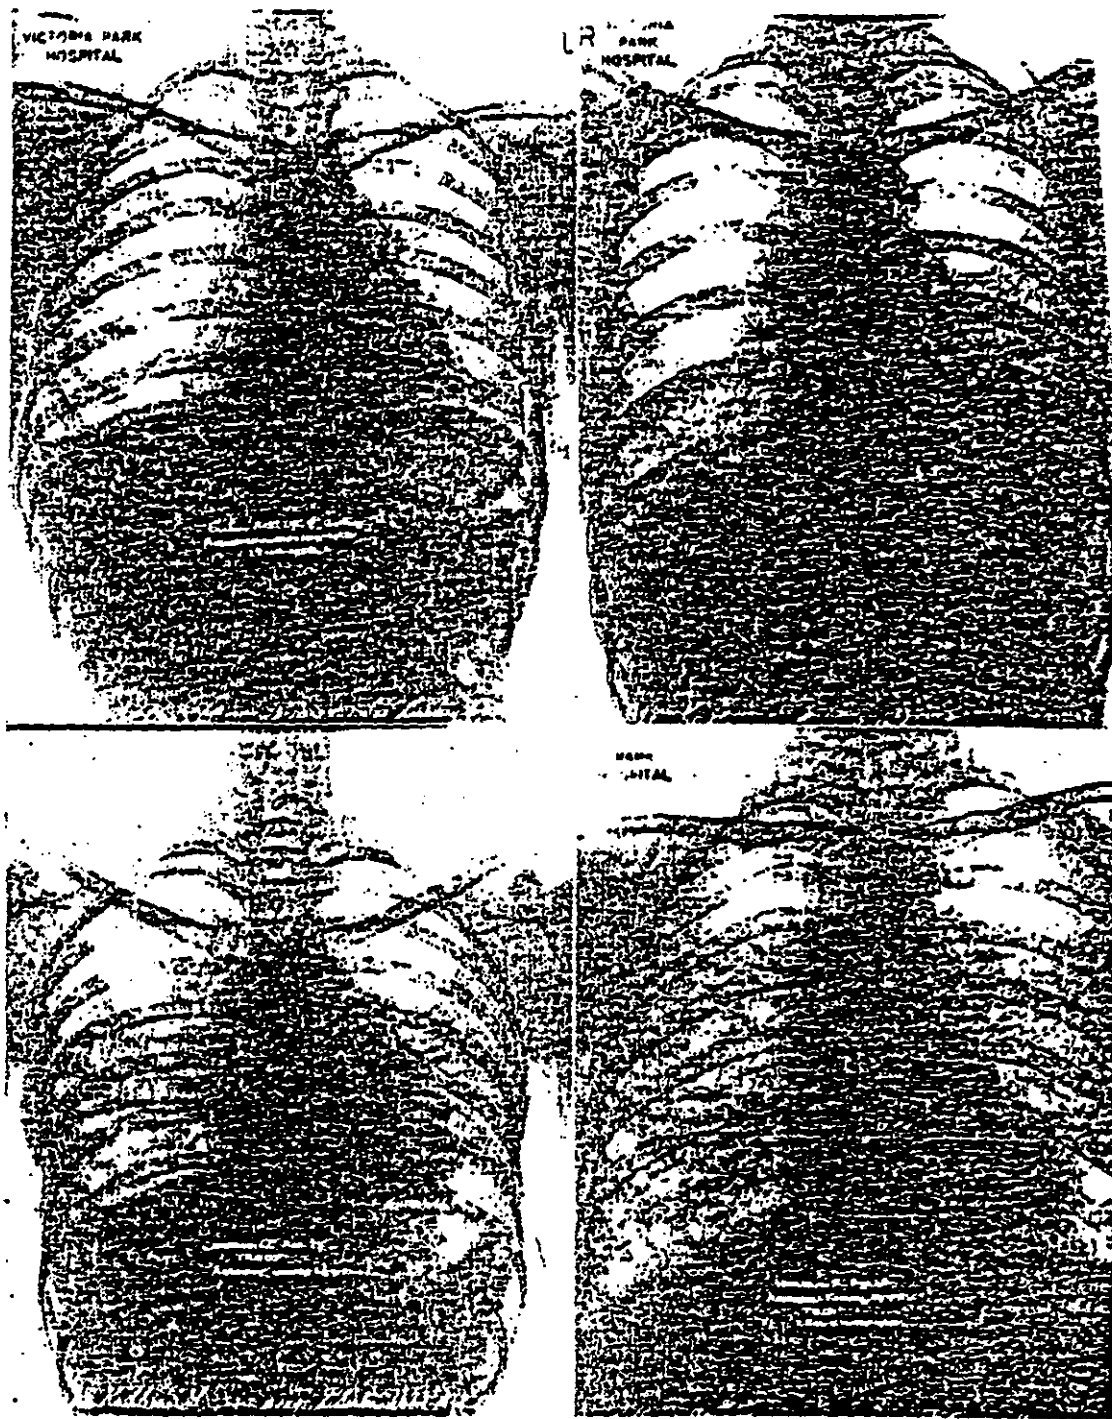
(upper left). Roentgenogram of chest of asbestos worker, exposed for four years.
